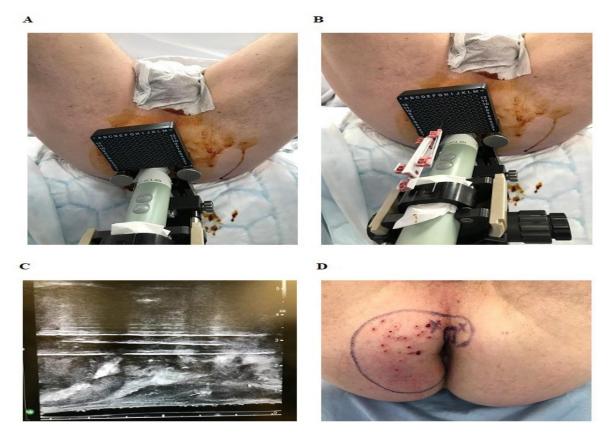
A: Demonstrating the angle of the ultrasound probe with the template grid, stabilised by the stepper, required to take biopsies from the right areas of the prostate. The probe is then adjusted slightly to take biopsies from the left areas of the prostate.
